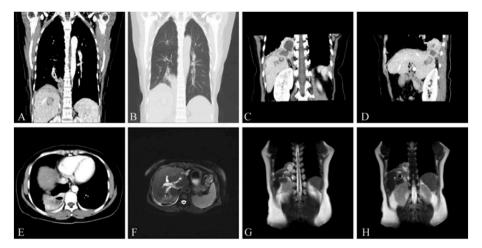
Image data, (A, B) chest high-resolution CT showed patchy high-density shadows in the lower lobe of the right lung, (C, D, E) chest and upper abdomen enhanced CT showed pulmonary abscess in the lower lobe of the right lung involving the right diaphragm and the lower diaphragm, and unclear affinity with the liver. (F,G,H) MRCP, intrahepatic bile duct calculi, and biliary tract dilation.
